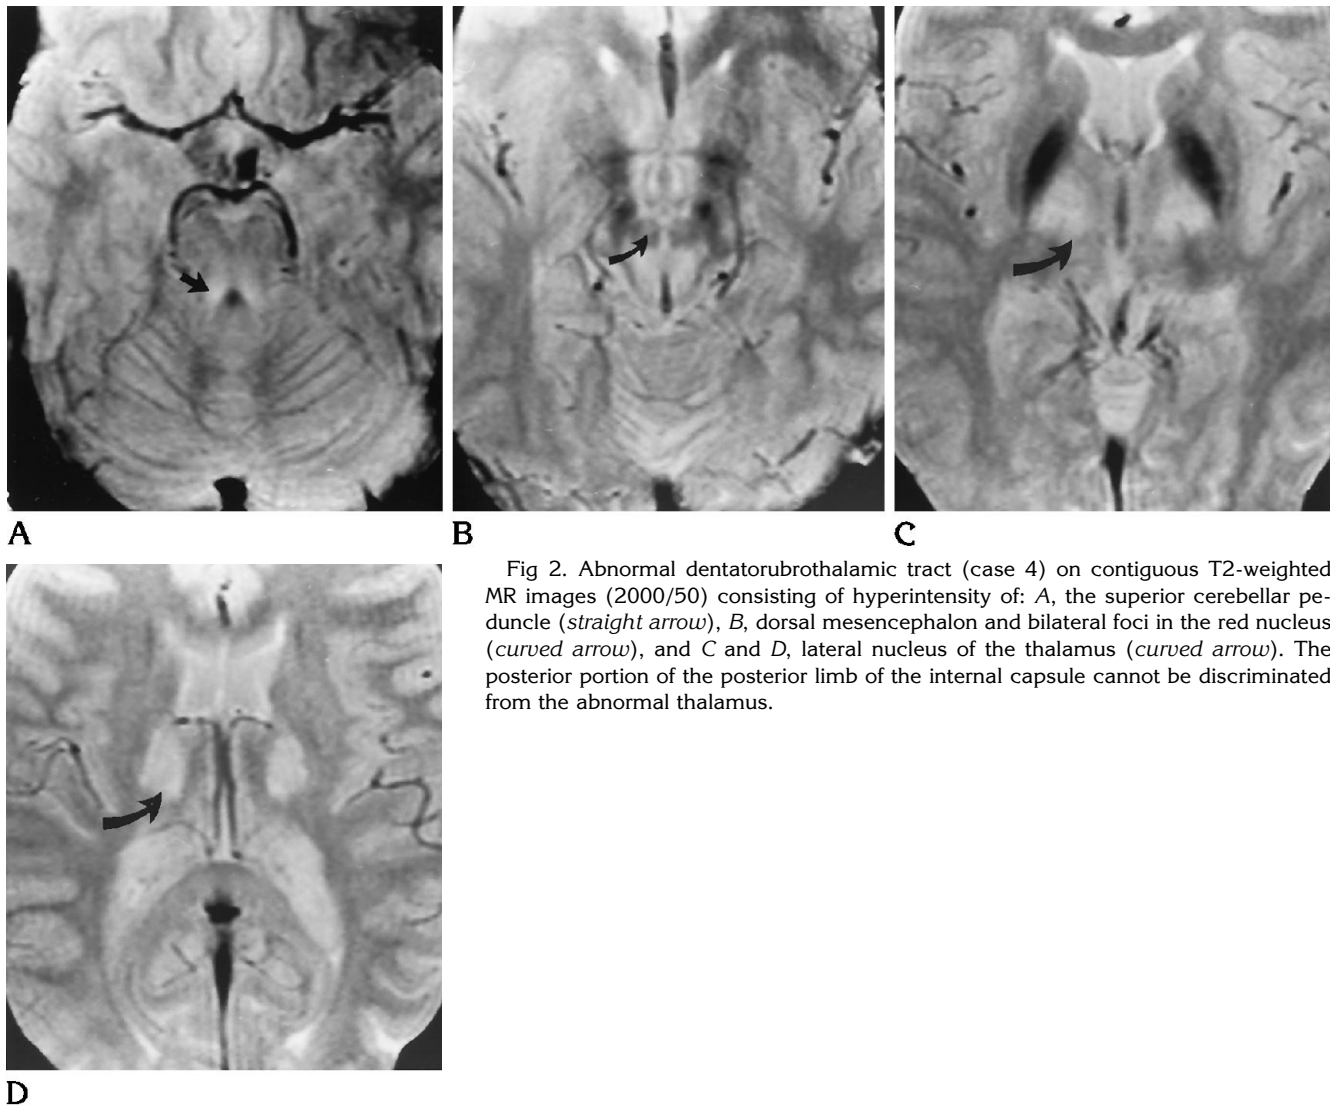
Abnormal dentatorubrothalamic tract (case 4) on contiguous T2-weighted MR images (2000/50) consisting of hyperintensity of: A, the superior cerebellar peduncle (*straight arrow*), B, dorsal mesencephalon and bilateral foci in the red nucleus (*curved arrow*), and C and D, lateral nucleus of the thalamus (*curved arrow*). The posterior portion of the posterior limb of the internal capsule cannot be discriminated from the abnormal thalamus.
